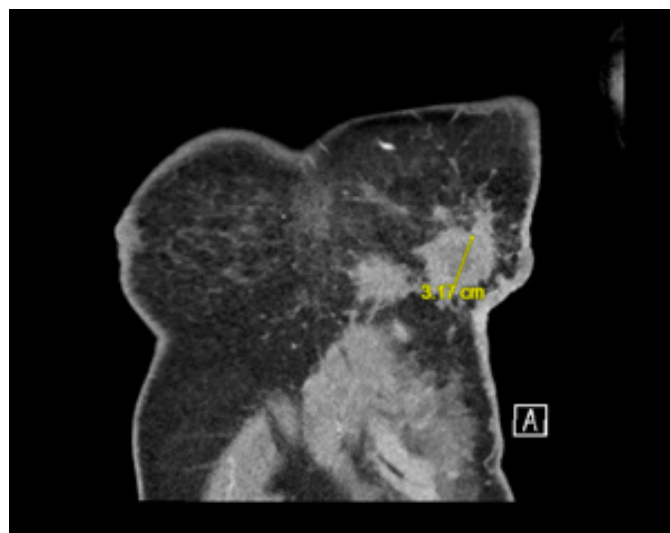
Coronal CT scan showing 3.17 cm left breast mass
